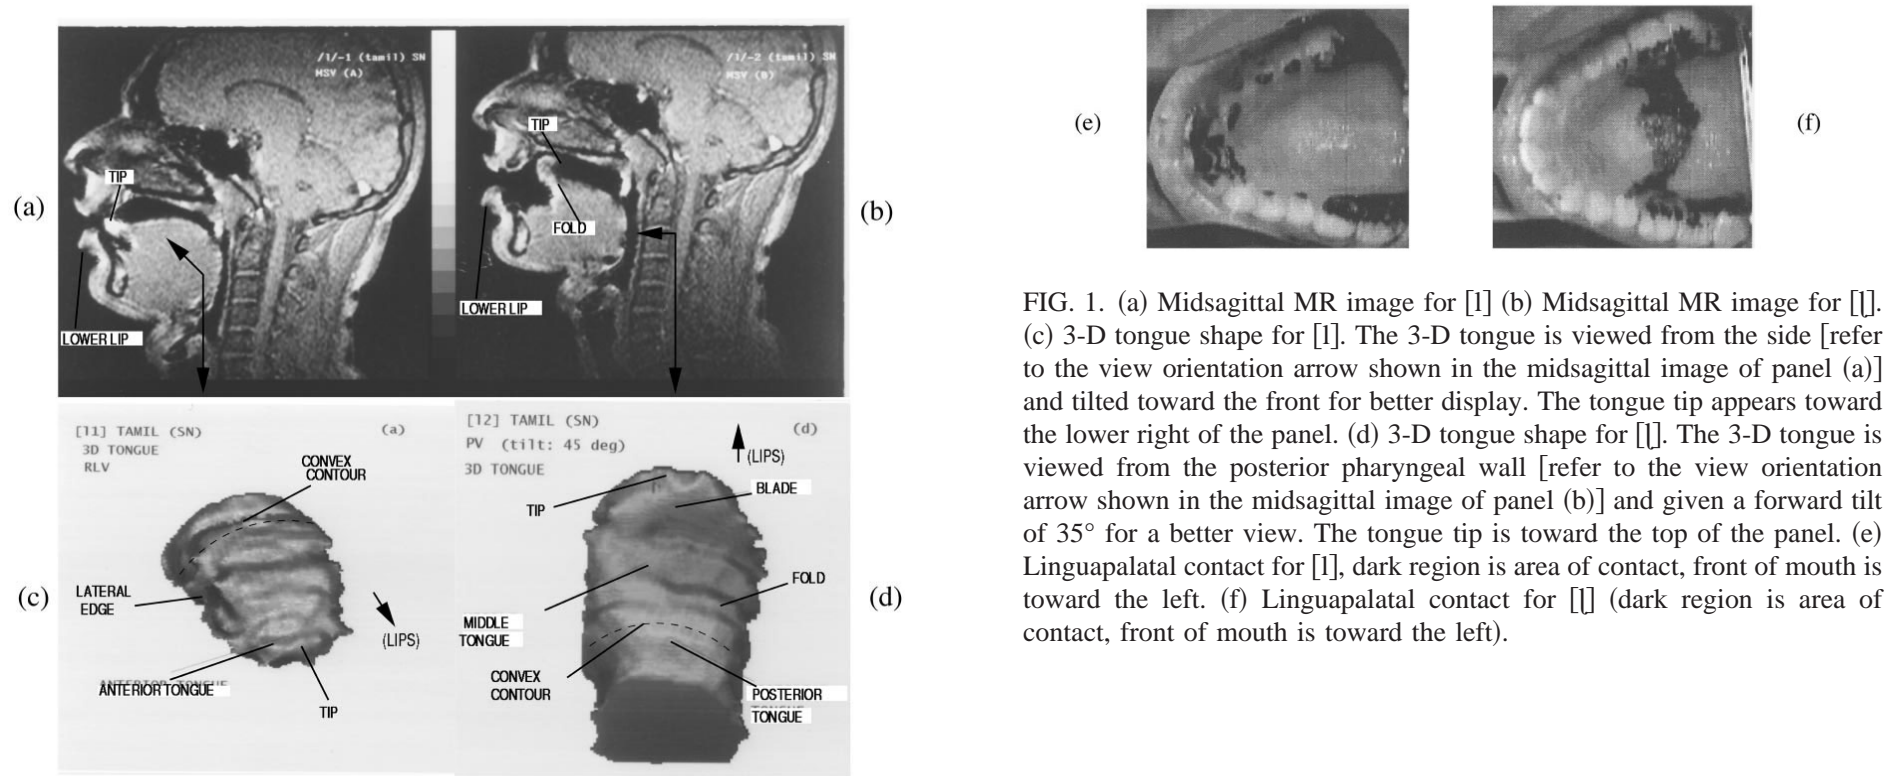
(a) Midsagittal MR image for [l] (b) Midsagittal MR image for [ɭ]. (c) 3-D tongue shape for [l]. The 3-D tongue is viewed from the side [refer to the view orientation arrow shown in the midsagittal image of panel (a)] and tilted toward the front for better display. The tongue tip appears toward the lower right of the panel. (d) 3-D tongue shape for [ɭ]. The 3-D tongue is viewed from the posterior pharyngeal wall [refer to the view orientation arrow shown in the midsagittal image of panel (b)] and given a forward tilt of 35° for a better view. The tongue tip is toward the top of the panel. (e) Linguopalatal contact for [l], dark region is area of contact, front of mouth is toward the left. (f) Linguopalatal contact for [ɭ] (dark region is area of contact, front of mouth is toward the left).
